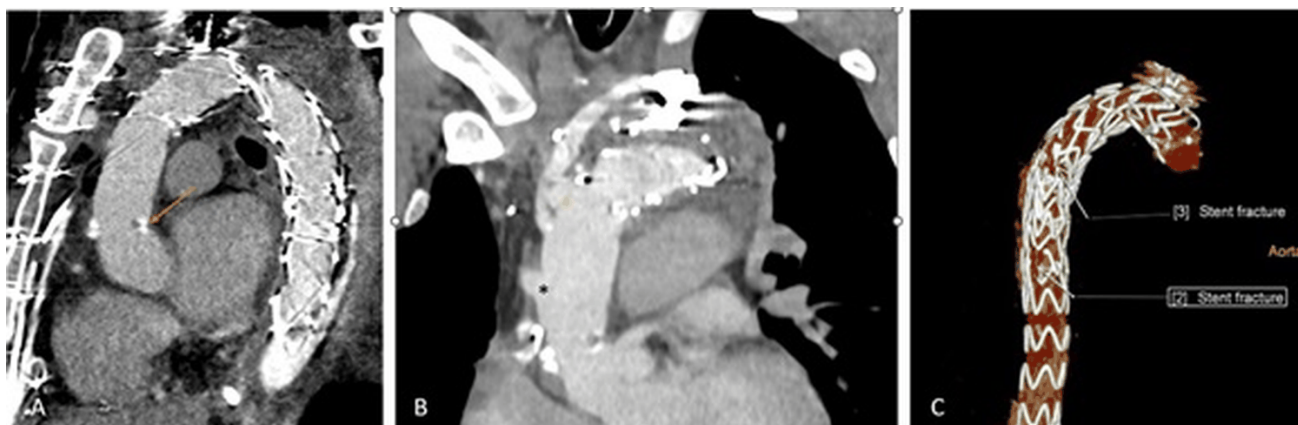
CT aortography after ascending aorta and total arch replacement with frozen elephant trunk surgery.
